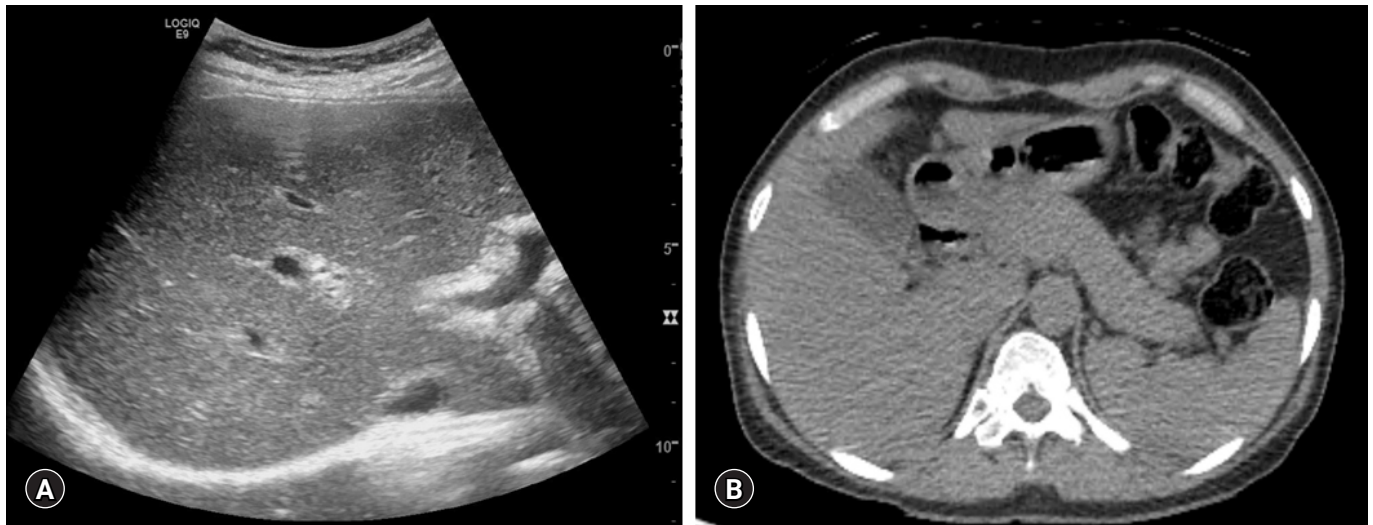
Abdominal sonography and computed tomography showing (A) increased echogenicity of the liver parenchyma with heterogeneous echotexture and (B) normal pancreas without significant evidence of autoimmune pancreatitis.
